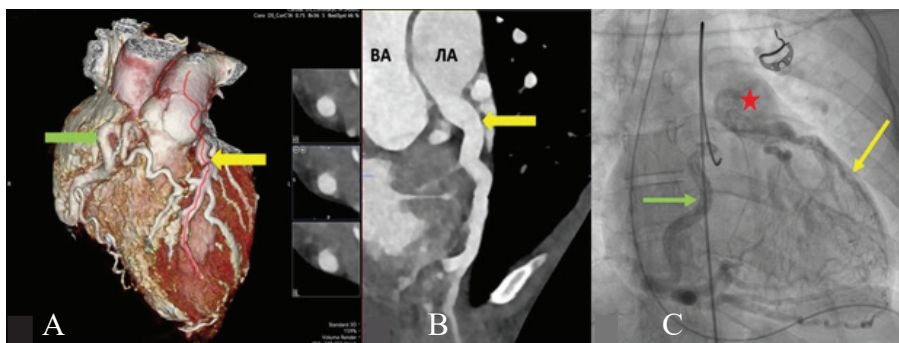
Preoperative CT of the heart and CAG: A and B - the trunk of the LCA departs from the PA (yellow arrow), RCA (green arrow); C - enlarged RCA (green arrow) retrograde fills the LCA basin (yellow arrow) and the pulmonary artery (red asterisk). BA is the ascending aorta, ЛА is the pulmonary artery
